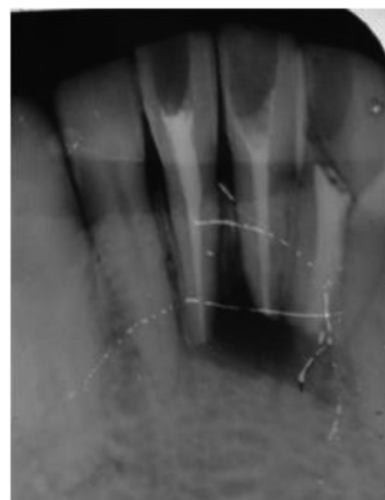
Immediate post-surgical radiograph wrt 32, 31, 41.
